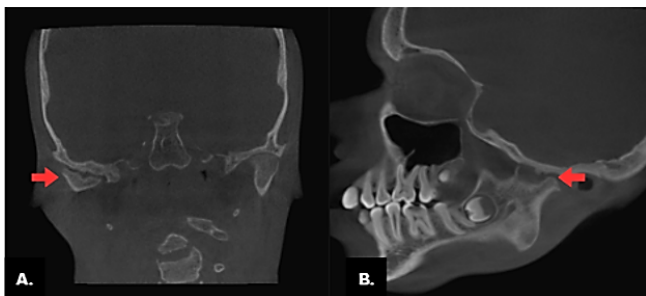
A. Coronal section showing irregular 'jigsaw-like' morphology of the condylar head. B. Sagittal CBCT section
